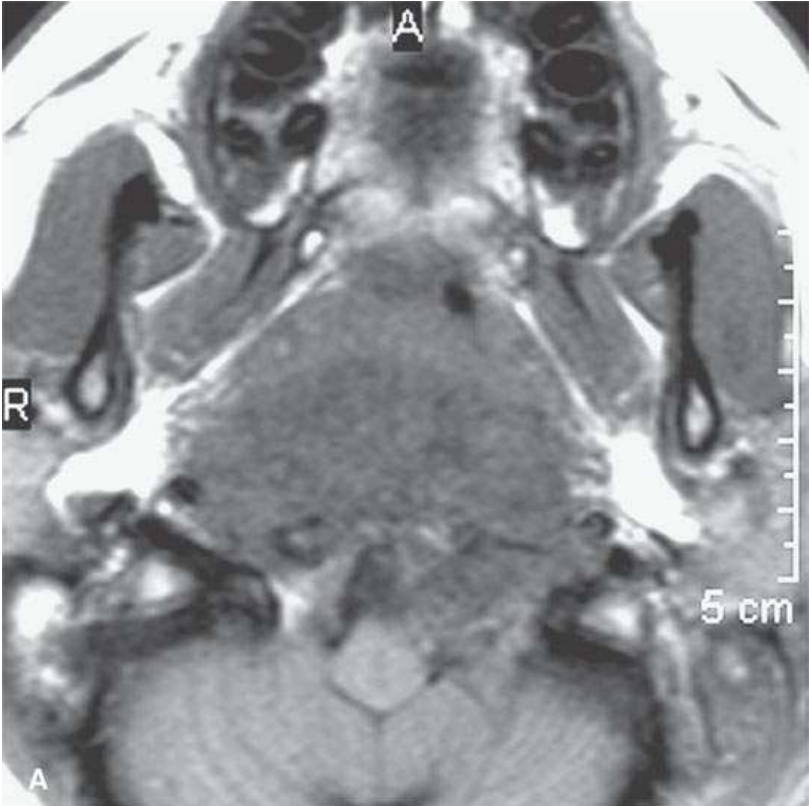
Magnetic resonance imaging studies showing the general tendency of tumors to grow as a spheroid unless constrained by surrounding anatomy. A: Contrast-enhanced T1-weighted (T1W) image of a tonsillar squamous cell carcinoma (*arrows*). B–D: Magnetic resonance and acinic cell parotid cancer (*arrows*)—non-contrast-enhanced T1W, T2-weighted, and contrast-enhanced T1W coronal, respectively. E, F: Non-contrast-enhanced T1W and contrast-enhanced T1W images of a parapharyngeal benign mixed tumor with the large egg-shaped tumor conforming in its midsection (*arrows*) as it extends through the stylomandibular tunnel. Note the tendency of the mass to displace surrounding structures such as the carotid artery (*arrowhead*) in a manner that suggests its site of origin and in that alone suggests a narrow differential diagnosis.
